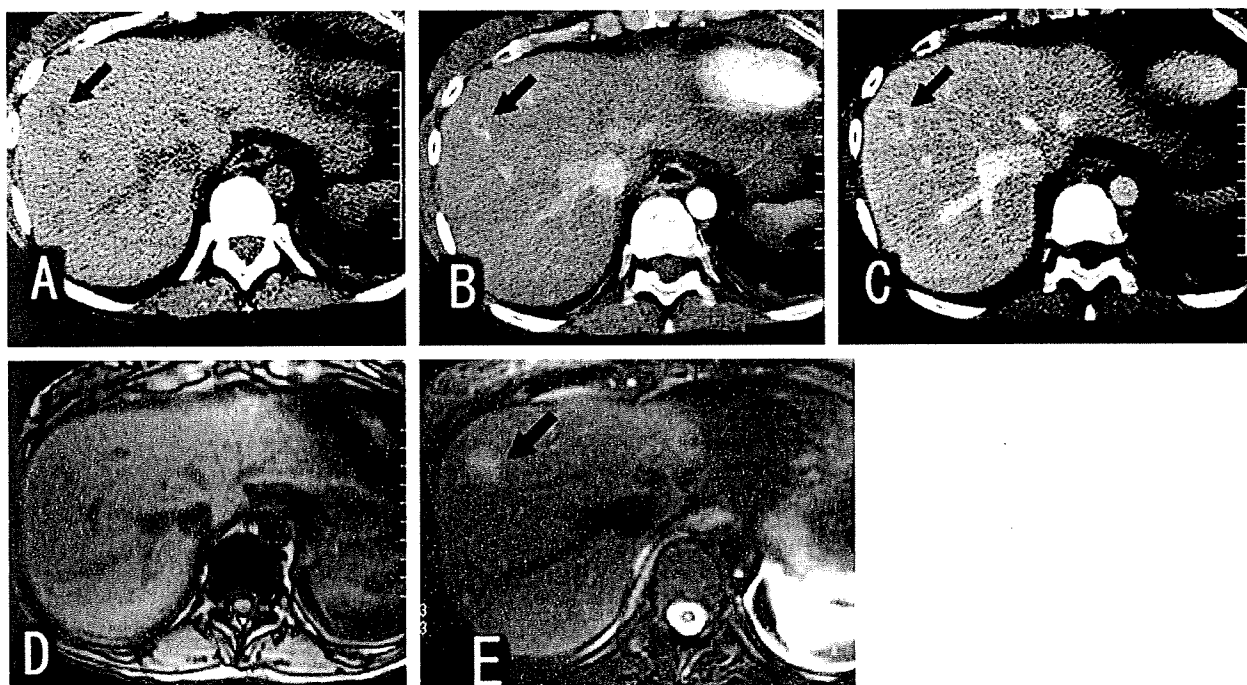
Regenerative nodules in a patient with collagen disease (arteritis). A Precontrast CT shows a hypodense nodule in the right lobe of the liver (*arrow*). B On an early arterial phase contrast-enhanced CT scan, the nodule shows enhancement compared to the surrounding liver (*arrow*). C On a portal phase contrast-enhanced CT scan, the nodule appears slightly hypodense relative
